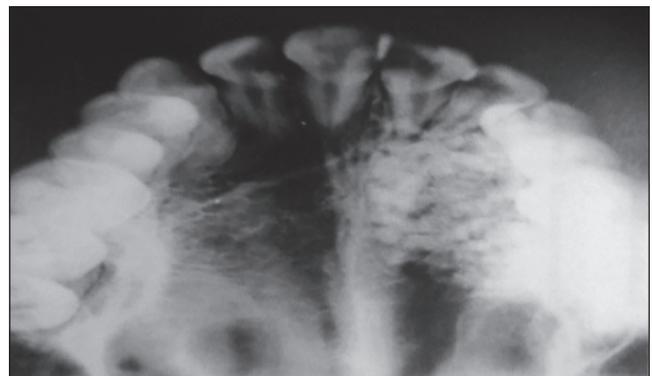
Postoperative radiograph after 3 months showing bone formation at the periphery
